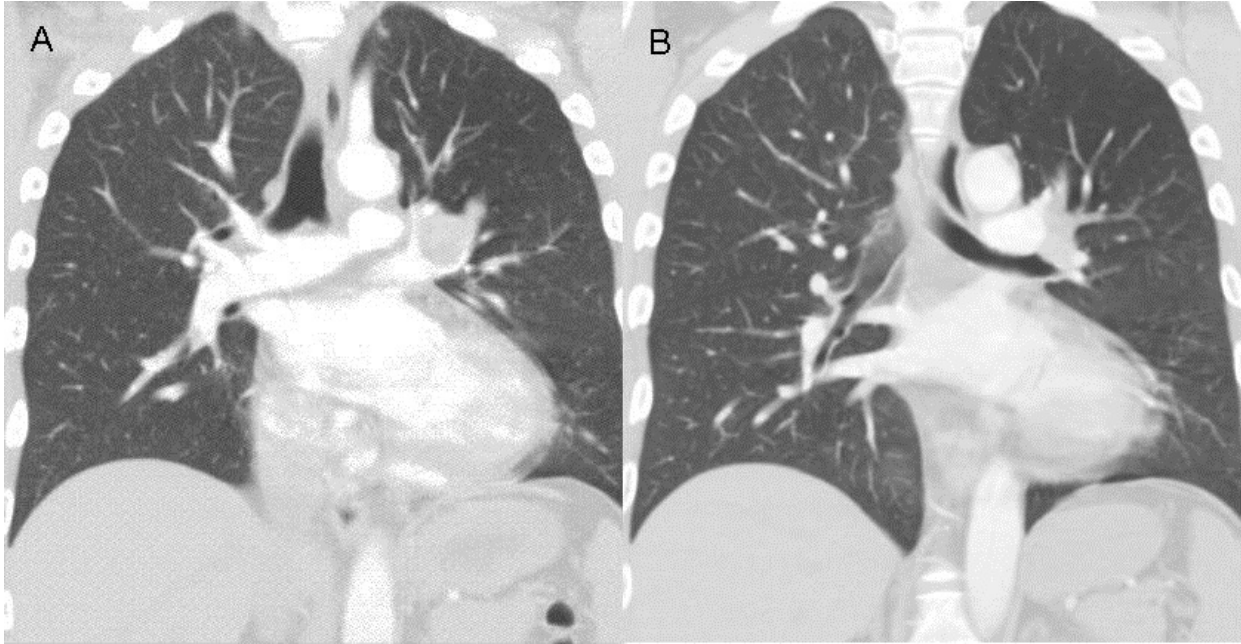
Coronal thoracic CT images (lung windows).
